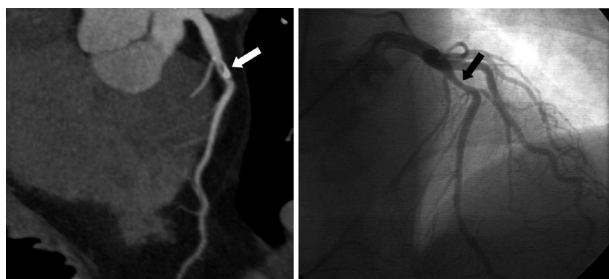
Example of discrepancy between multidetector CT (MDCT) and cardiac catheterization. MDCT image on the left showed a calcified lesion (left image, arrow) at proximal anterior descending artery with estimated stenosis > 70% which was quantified as less than 50% by cardiac catheterization (right image, arrow).
